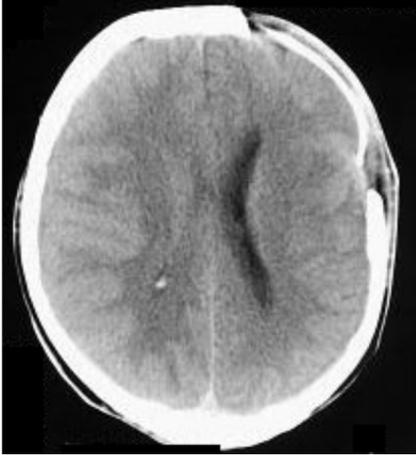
Computed tomography of the head. State after evacuation of the epidural haematoma and removal of the bone fragment.
